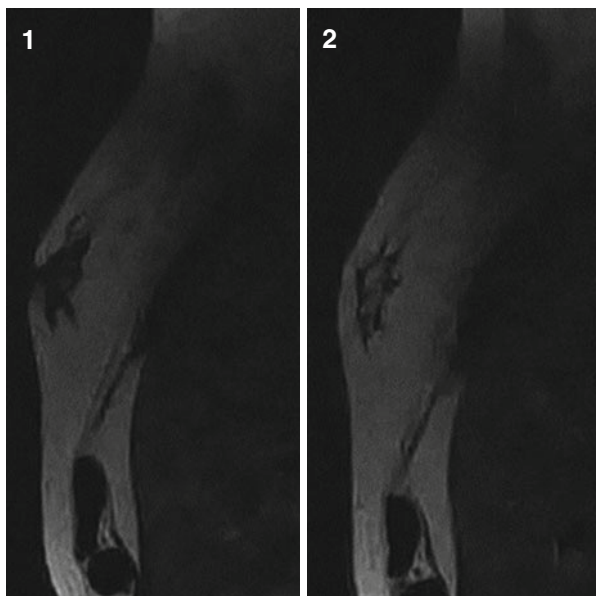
(1, 2) MRI. T2-weighted fast relaxation, fast spin echo (T2FRFSE) sequence. Nodular gynecomastia
